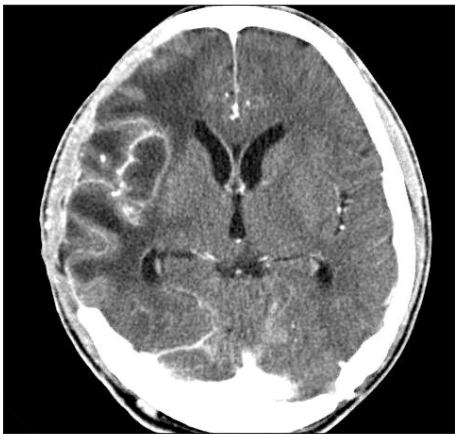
Contrast enhanced CT scan taken 3 weeks later reveals appearance of an intracerebral abscess with a thin walled cavity.
